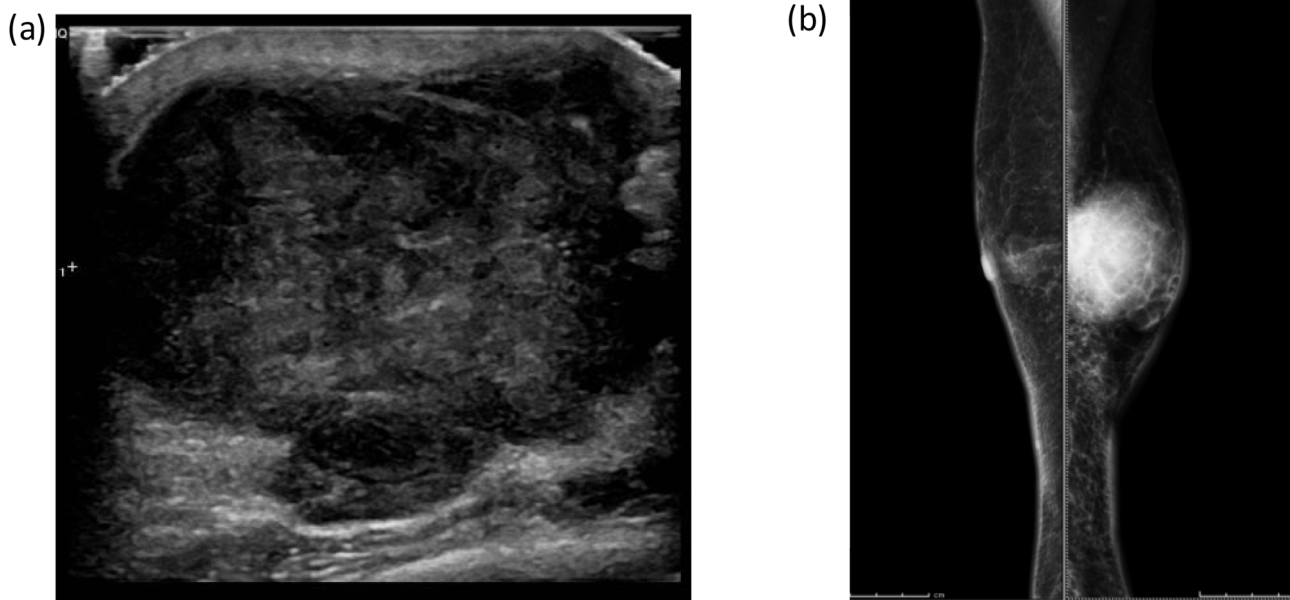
(a) Ultrasound at original presentation showing an excess of 50 mm abscess in the left retroareolar region that failed to yield any aspirate fluid. Clinical management was recommended. (b) Medio-Lateral Oblique mammographic view showing a well margined round 60 mm mass with overlying skin thickening on the left breast. The appearances are consistent with an inflammatory left breast carcinoma.
